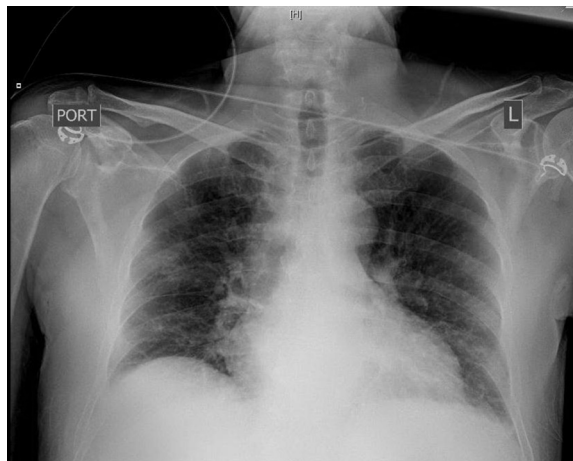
Admission chest roentgenogram.
